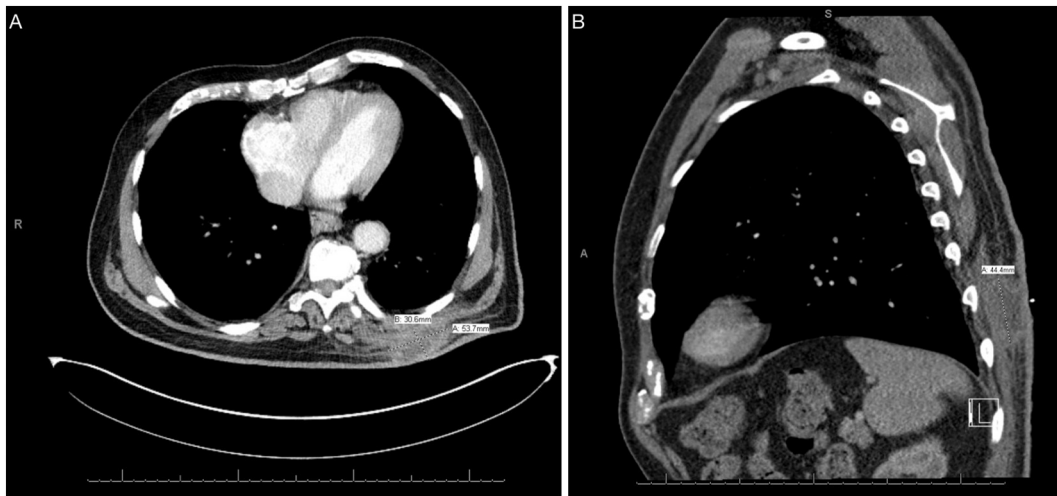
Computed tomography scan with intravenous contrast, showing (A transverse, B sagittal) a subcutaneous soft-tissue mass in the posterior left back that measures $5.4 \times 3.0 \times 4.4$ cm. The center is hypodense, and inflammatory changes surround the mass. The mass extends from the skin into the lower trapezius muscle without underlying bone involvement.
